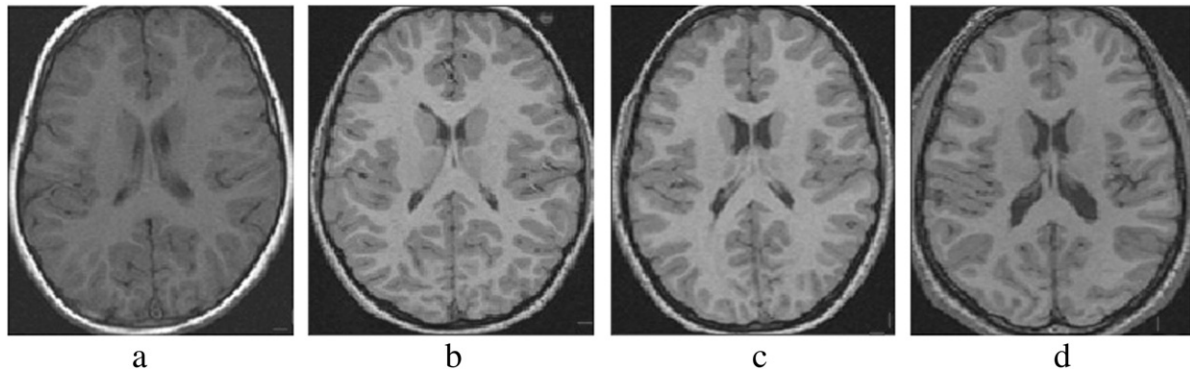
MR images of children brains from 4 to 18 years old. (a) 4 years old, (b) 8 years old, (c) 12 years old, and (d) 18 years old.
